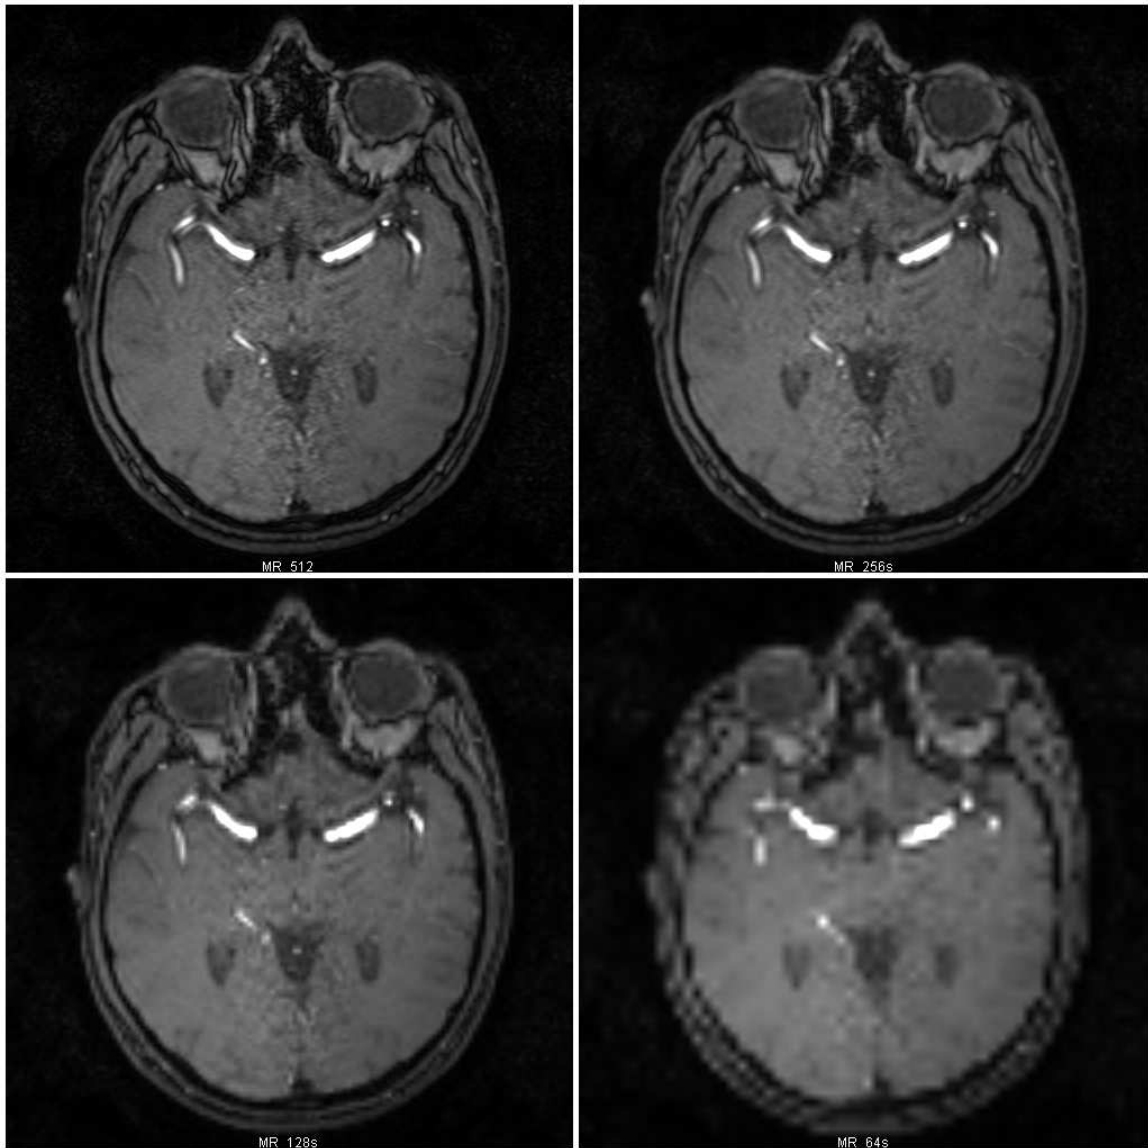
Successively downsampled MRI images. (Courtesy of SINTEF MedTech)
